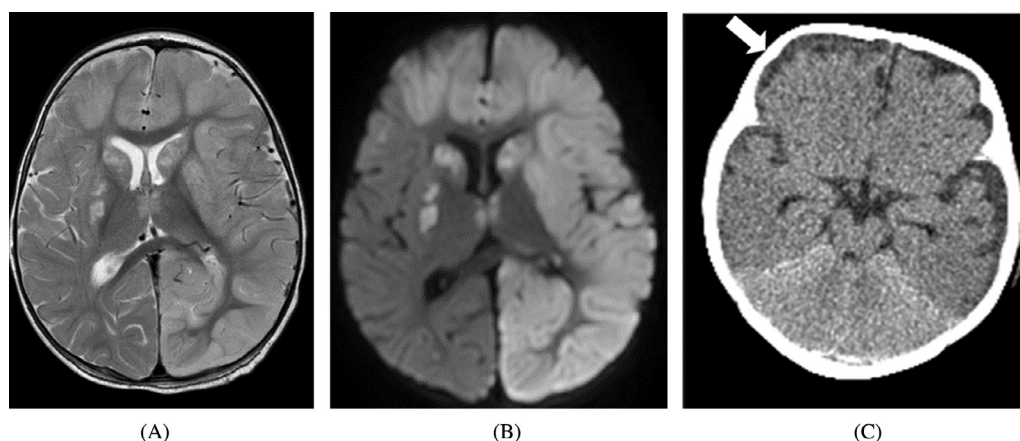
Hypoxic ischemic injury. (A) T2, and (B) DWI axial images from a brain MRI examination of 7 months old (same patient as in Fig. 2), demonstrating bilateral infarcts involving the majority of the left cerebral hemisphere and the right frontal lobe, bilateral lentiform nuclei and medial thalami. (C) Axial cut from a brain CT scan of a 4 months old male, subjected to AHT, who presented with unresponsiveness, demonstrates diffuse hypodensity of the cerebrum with loss of gray white matter differentiation and a preserved cerebellum, consistent with the “reversal” sign. In addition there is a right frontal SDH (arrow).
